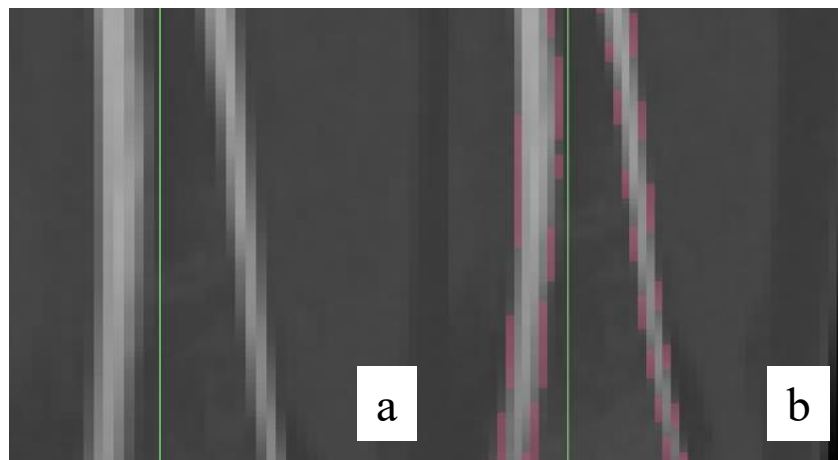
Above is a portion of the shaft of the femur from Case 332's unenhanced CT scan. Both (a) and (b) depict the same region of bone from the same scan where (b) has the trabecular mask (pink) displayed. The trabecular mask region along the shaft is applied to areas where a partial volume effect is expected to have occurred.
